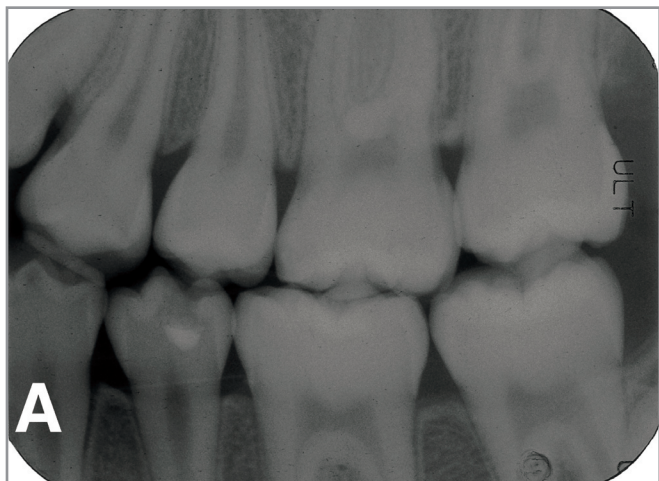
(a) Bitewing radiograph of the mandibular left second premolar at 18 months after treatment (age 13 years, years 8 months) showing a layer of sound dentin separating the pulp and the filling. (b) Periapical radiograph of the permanent mandibular left second premolar at age 13 years, years 8 months showing continuing root formation.
